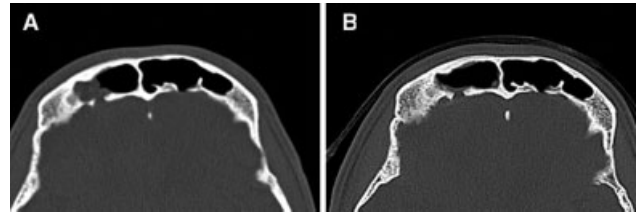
Pre-operative CT scan (A) demonstrated defect in posterior wall of right frontal sinus with encephalocele which was repaired by transorbital endoscopic approach. At 6 months, there was no evidence of CSF leak. The defect was completely reconstructed with patency of the frontal sinus shown in the follow-up CT scan (B).
